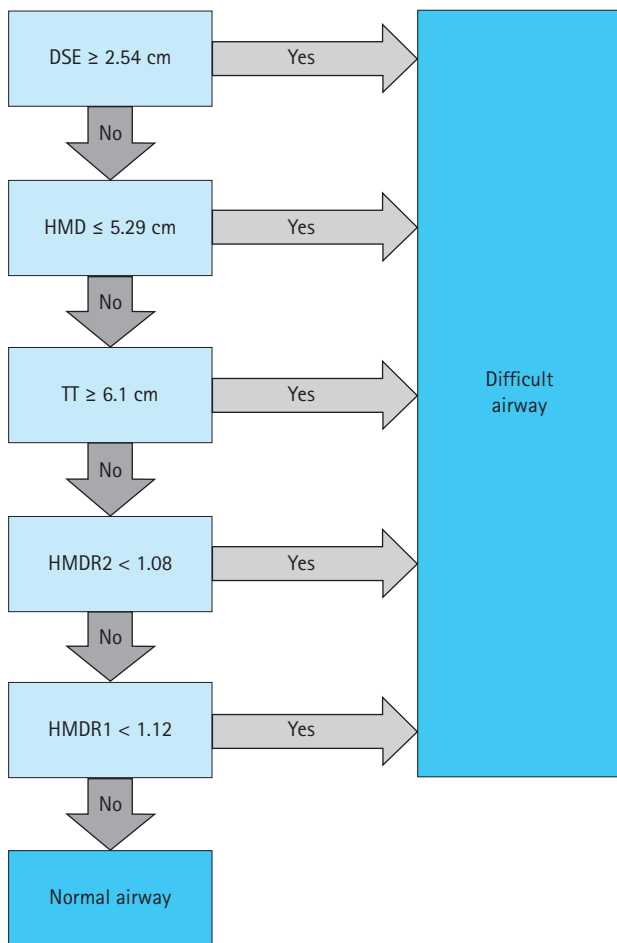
Difficult Airway Evaluation with Sonography (DARES) algorithm. DSE, distance from the skin to the epiglottis; HMD, hyomental distance; TT, tongue thickness; HMDR2, ratio of the HMD measured with the head in maximal extension and the head in neutral position; HMDR1, ratio of the HMD measured with the head in a ramped position and the head in neutral position. Adapted from Lin et al. [21], available under the Creative Commons License.
